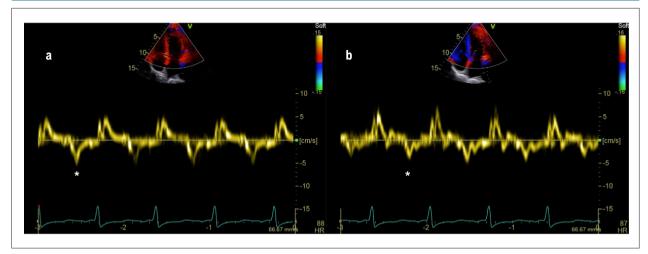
Tissue Doppler images of the mitral annulus. There is E' wave(*) deceleration in both the medial (a) and lateral (b) mitral annulus. Both speeds are below 4 cm/s (right ventricle > 8 cm/s). (Images from the authors' personal archive).
